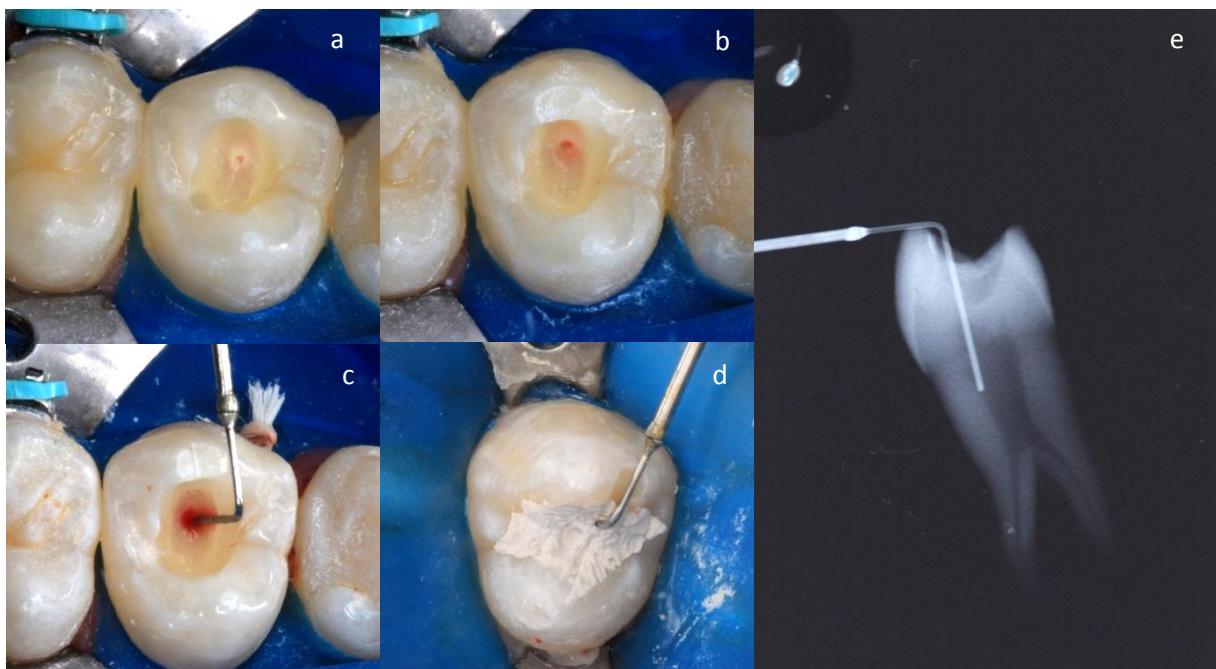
1a- pré-molar com acesso oclusal próximo à exposição, 1b- exposição concluída com sonda exploradora, 1c- inserção da sonda do termopar no interior da câmara pulpar, 1d- obturação do acesso com material restaurador provisório e 1e- radiografia periapical após a extração dentária ilustrando a provável posição da sonda do termopar no interior da câmara pulpar.
